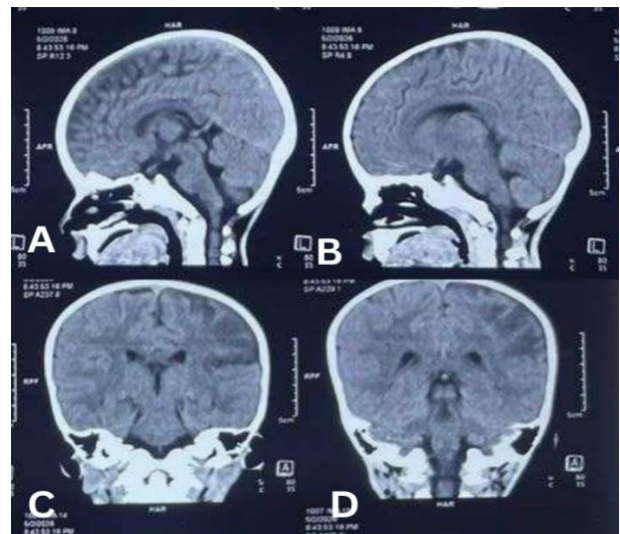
(A-D) Non-contrast CT brain (coronal and sagittal section) showing encephalomalacic change with gyriform (dystrophic) calcification and mild hemiatrophy of the left fronto-parieto-temporal region, reflecting chronic ischaemic injury.
